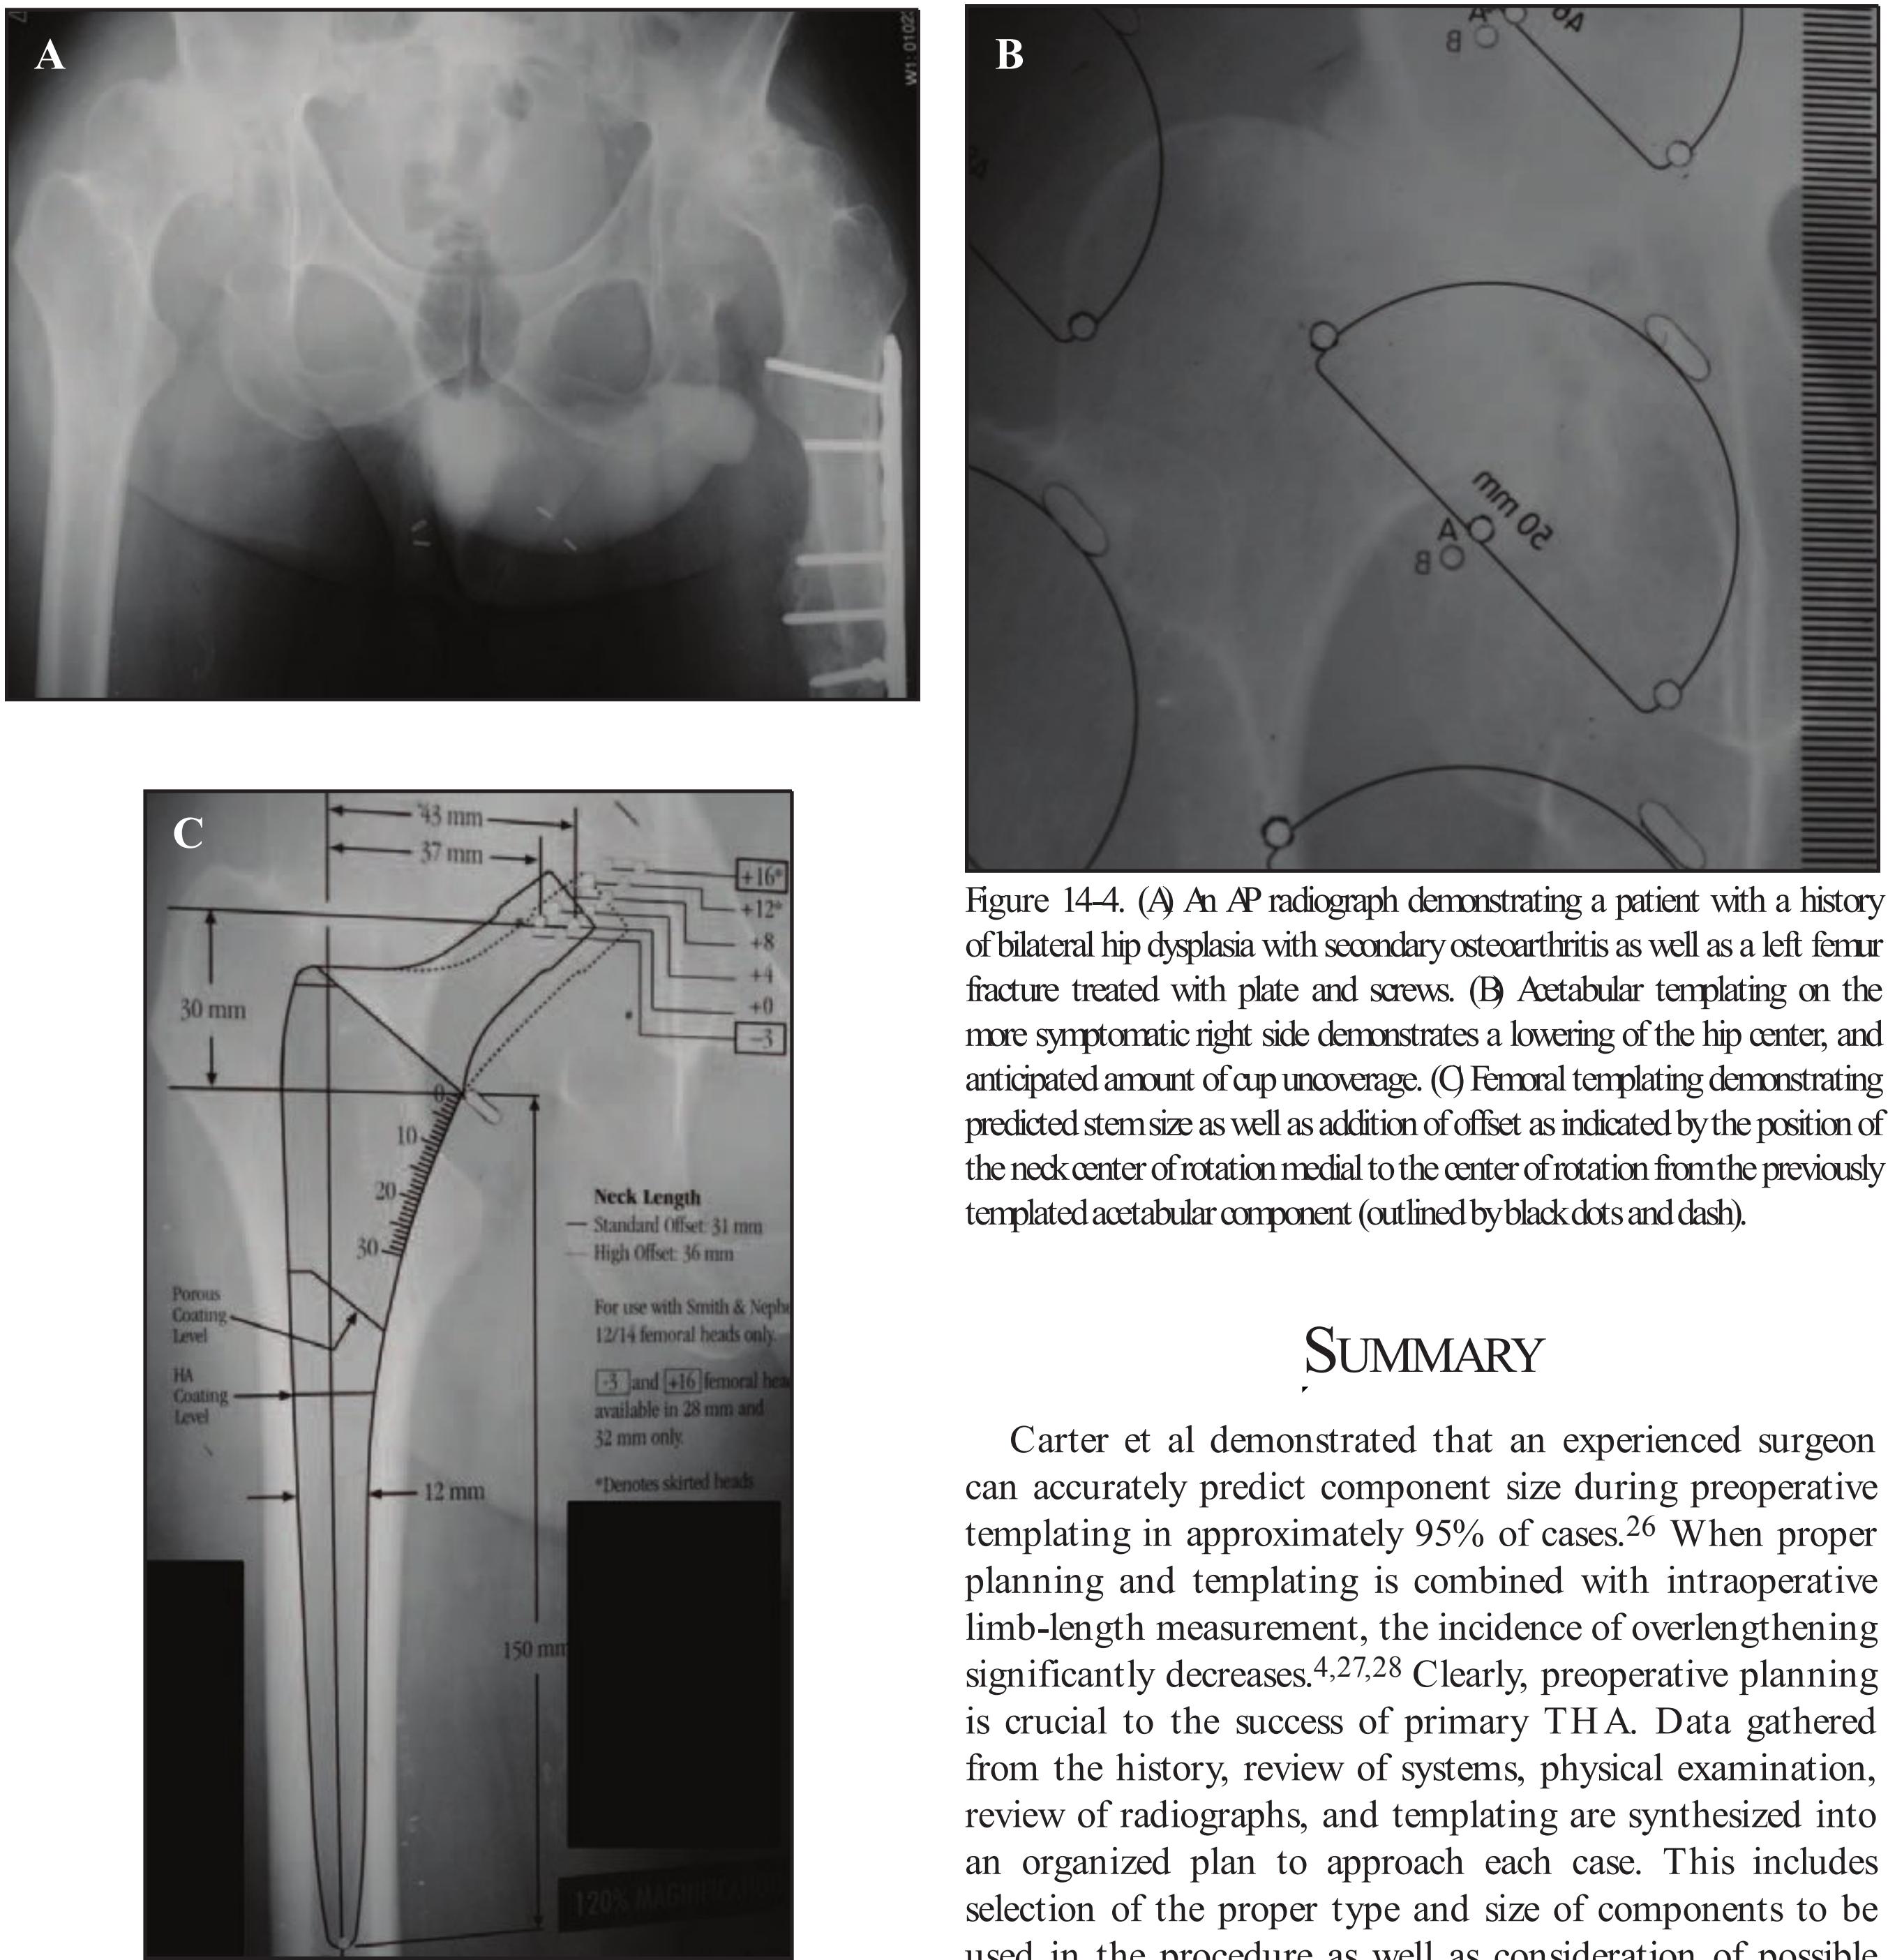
(A) An AP radiograph demonstrating a patient with a history of bilateral hip dysplasia with secondary osteoarthritis as well as a left femur fracture treated with plate and screws. (B) Acetabular templating on the more symptomatic right side demonstrates a lowering of the hip center, and anticipated amount of cup uncoverage. (C) Femoral templating demonstrating predicted stem size as well as addition of offset as indicated by the position of the neck center of rotation medial to the center of rotation from the previously templated acetabular component (outlined by black dots and dash).
